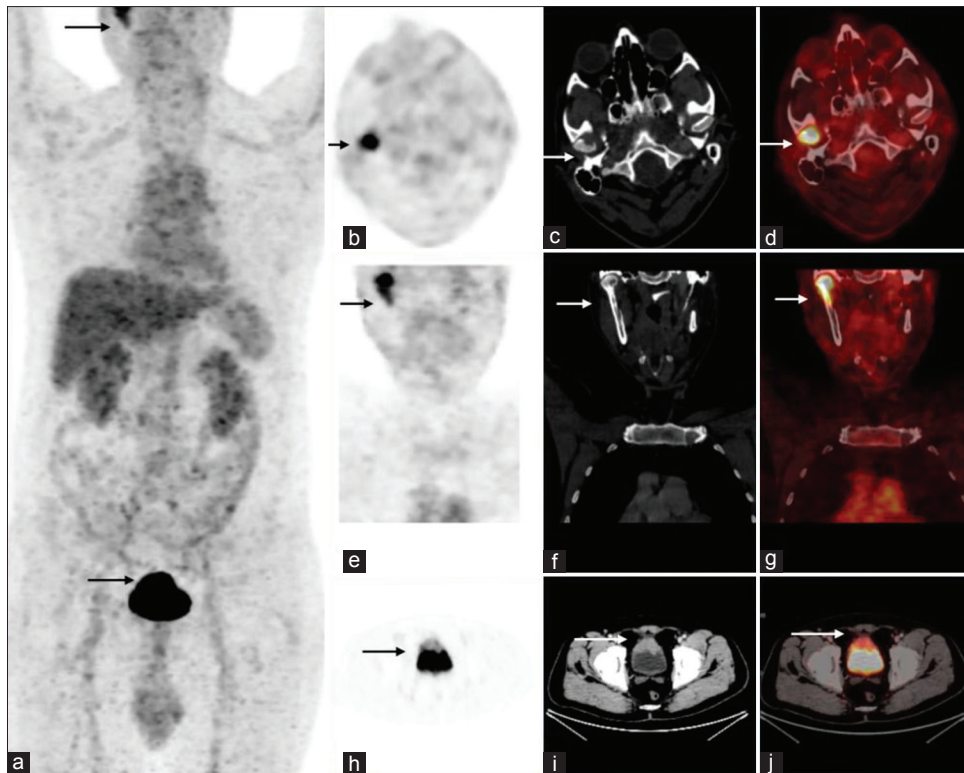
MIP (a) image of staging whole-body PET-CT scan, showing primary FDG avid lesions. Axial (h-j) PET, CT, and fused PET images showing FDG avid lesions involving anterior wall of urinary bladder. Apart from primary lesion, FDG avid erosion of condylar process of the right mandible was seen in axial and coronal (b-g) PET, CT, and fused images
